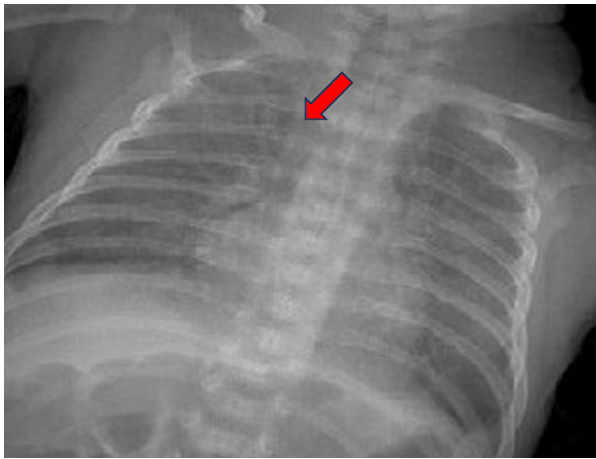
X-ray image of P6 showing the absence of the thymus gland.
